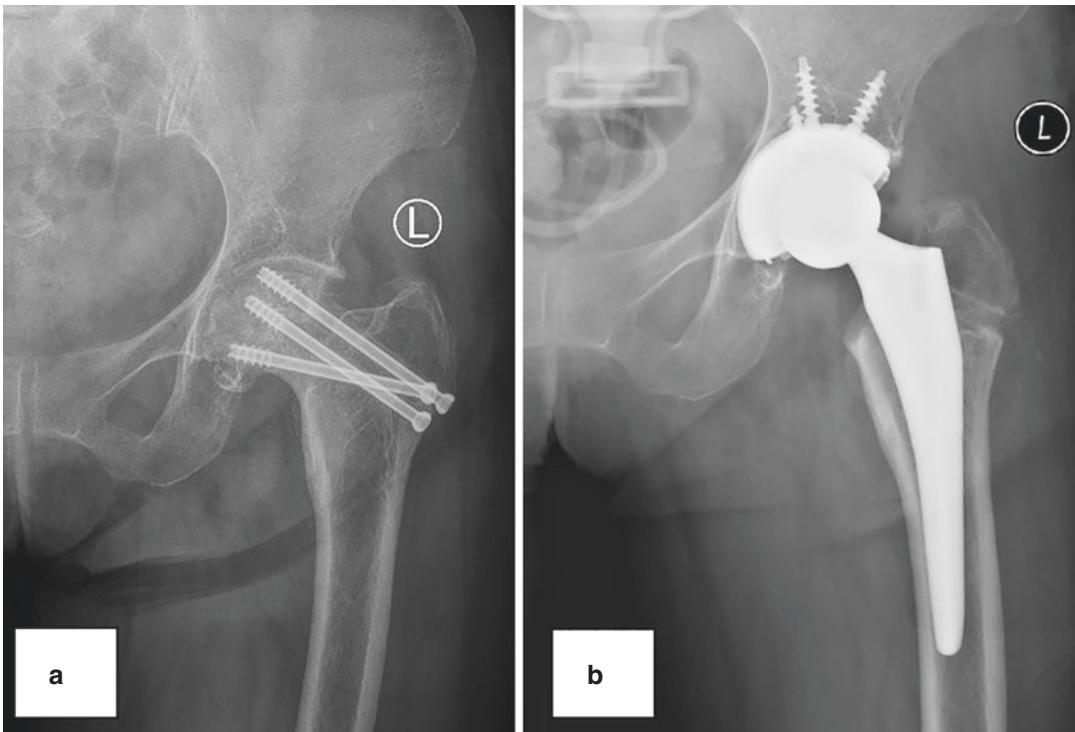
(a) Anteroposterior radiograph of a 58-year-old woman with an osteonecrosis of femoral head 2 years after fixation with cannulated screws for femoral neck
